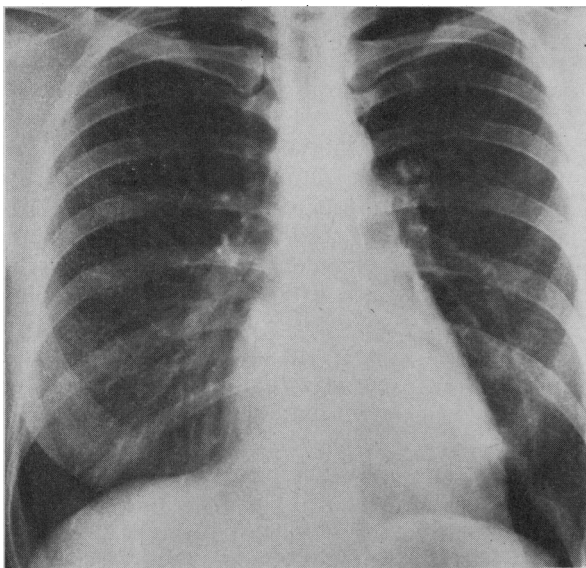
Radiograph of heart and lungs immediately before operation.
